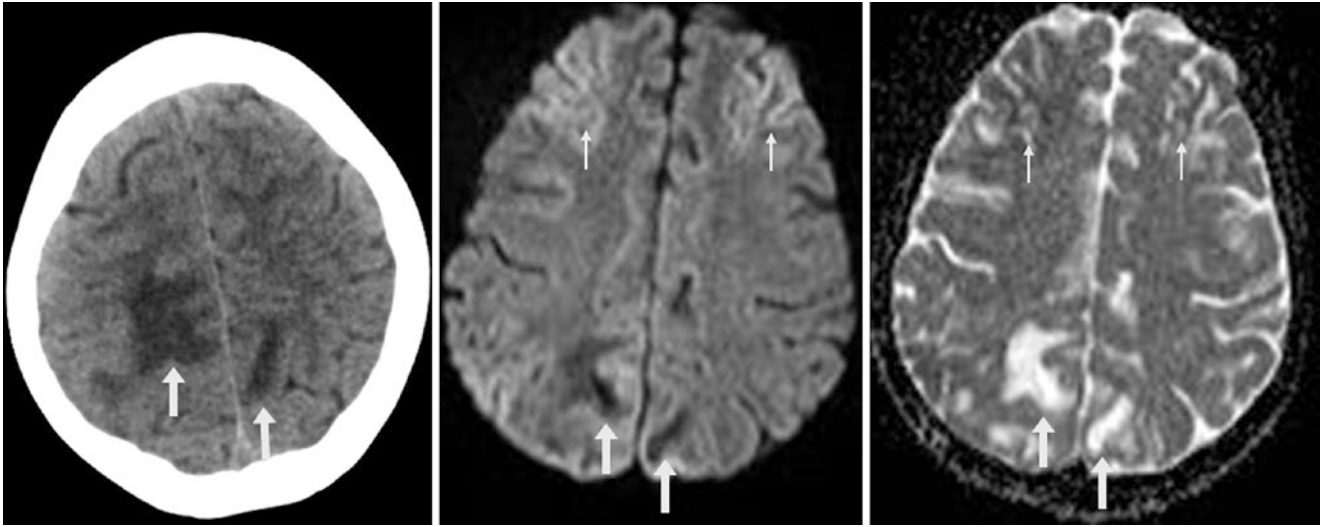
An 11-year-old with bilateral parieto-occipital edema (arrows) of PRES (due to cyclosporine toxicity) on nonenhanced CT (left). On a 3 T MRI, there is dark signal on DWI (middle) and bright signal on the corresponding ADC map (right). Such “T2 washout”
